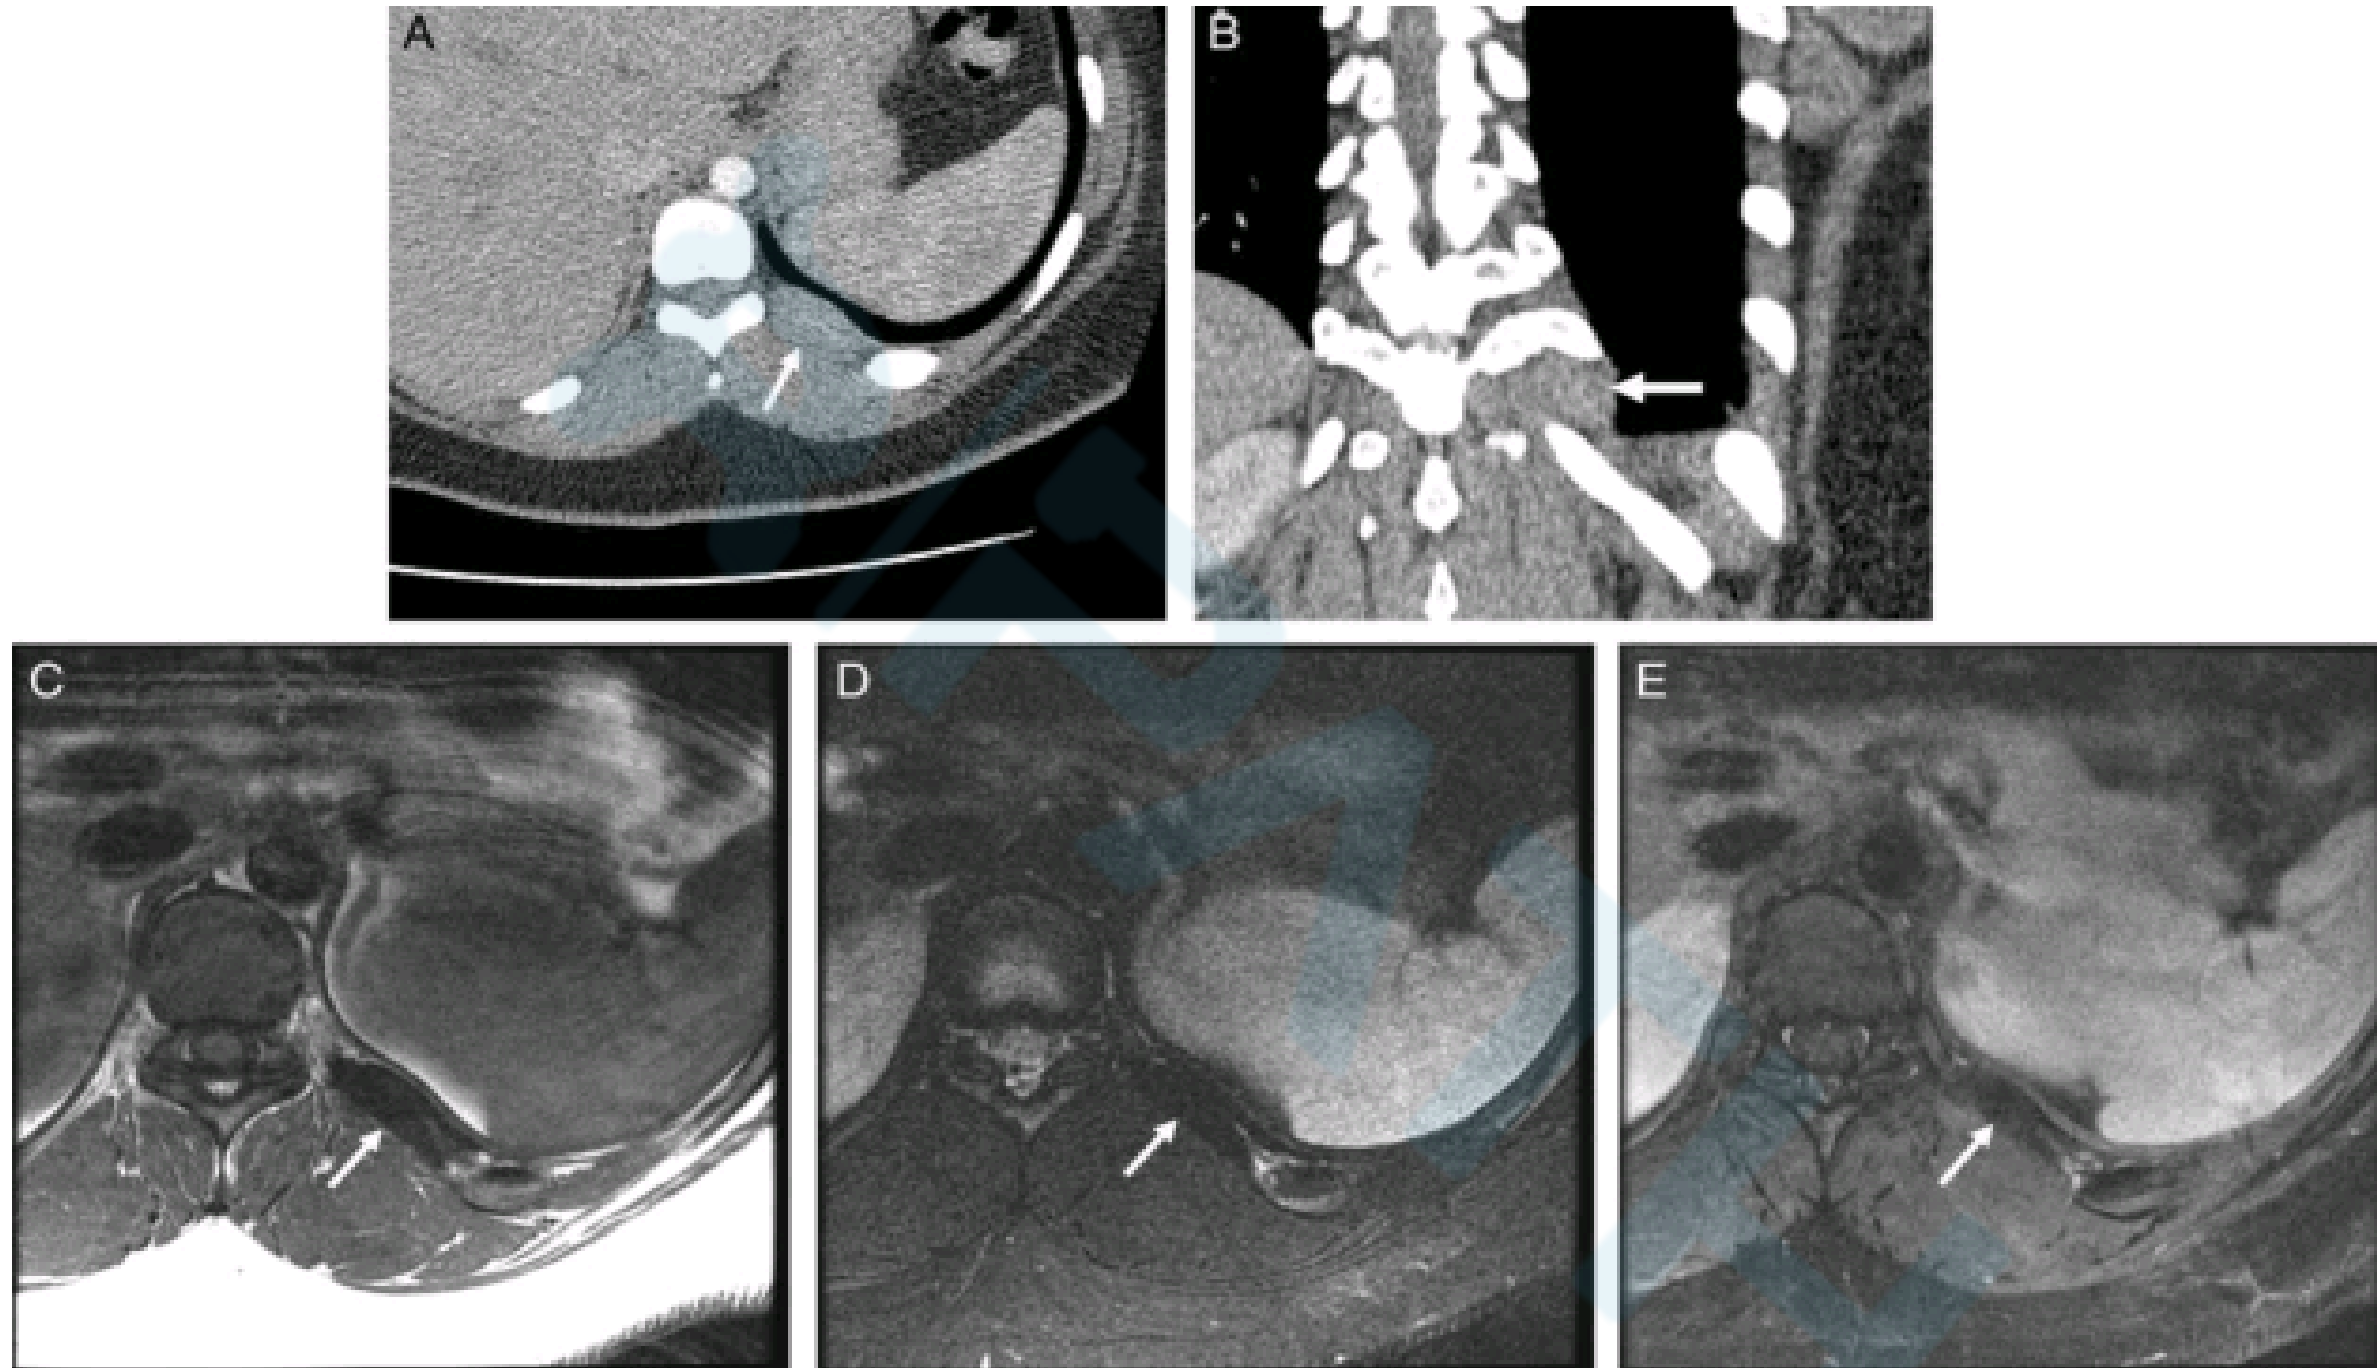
Case 2. Axial (A) and coronal reformatted (B) computed tomography images of the chest wall demonstrate a mildly hyperdense soft tissue mass, measuring 1.1 cm anteroposterior $\times$ 3.2 cm transverse $\times$ 2.0 cm SI, located between the left 10th and 11th ribs along the posterior-medial aspect of the chest wall, abutting the pleura (arrows). On magnetic resonance imaging, the mass is hypointense on axial T1 (C) and fat-suppressed T2 (D) weighted images and demonstrates no enhancement (E) (arrows). There is no evidence of invasion into the adjacent osseous or soft tissue structures.
